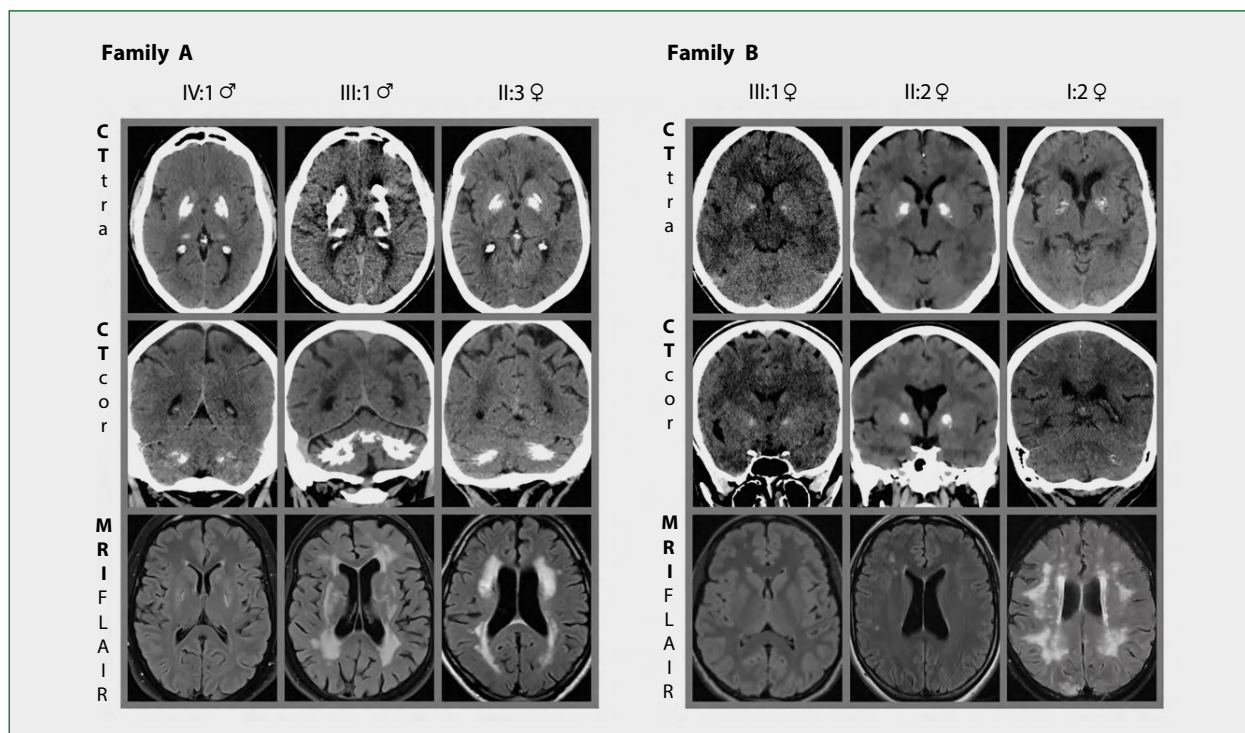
Radiological examinations of families A and B. Computed tomography (CT) scans from affected individuals in family A show bilateral calcifications in basal ganglia and cerebellum, while in family B they are present in basal ganglia of all three affected individuals; only discrete calcifications in the cerebellum are noted. Magnetic resonance imaging (MRI) shows white matter hyperintensities in all six mutation carriers. Both calcifications and small vessel disease are more prominent in older individuals
